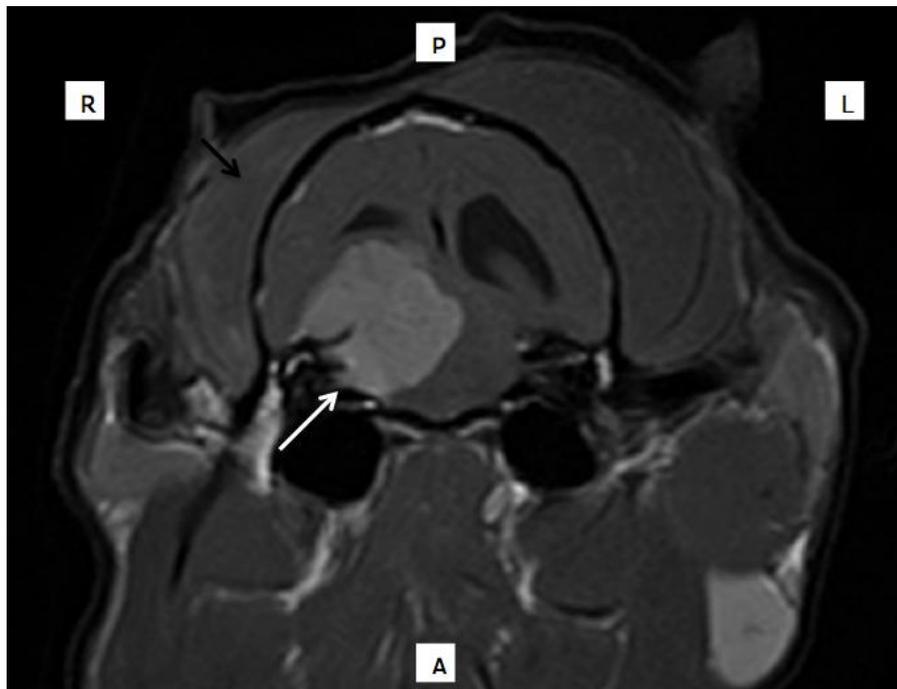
Transverse contrast MRI of a 7-yr-old female leopard (*Panthera pardus fusca*) showing homogenous enhancement of cranial nerves VII and VIII with the rest of the cerebello-pontine angle mass (white arrow). Severe atrophy of the Temporalis muscle can be appreciated on the right (black arrow), due to mass effect on the pons. Orientation of transverse images is denoted by A= anterior, P= posterior, R=right and L=left.
